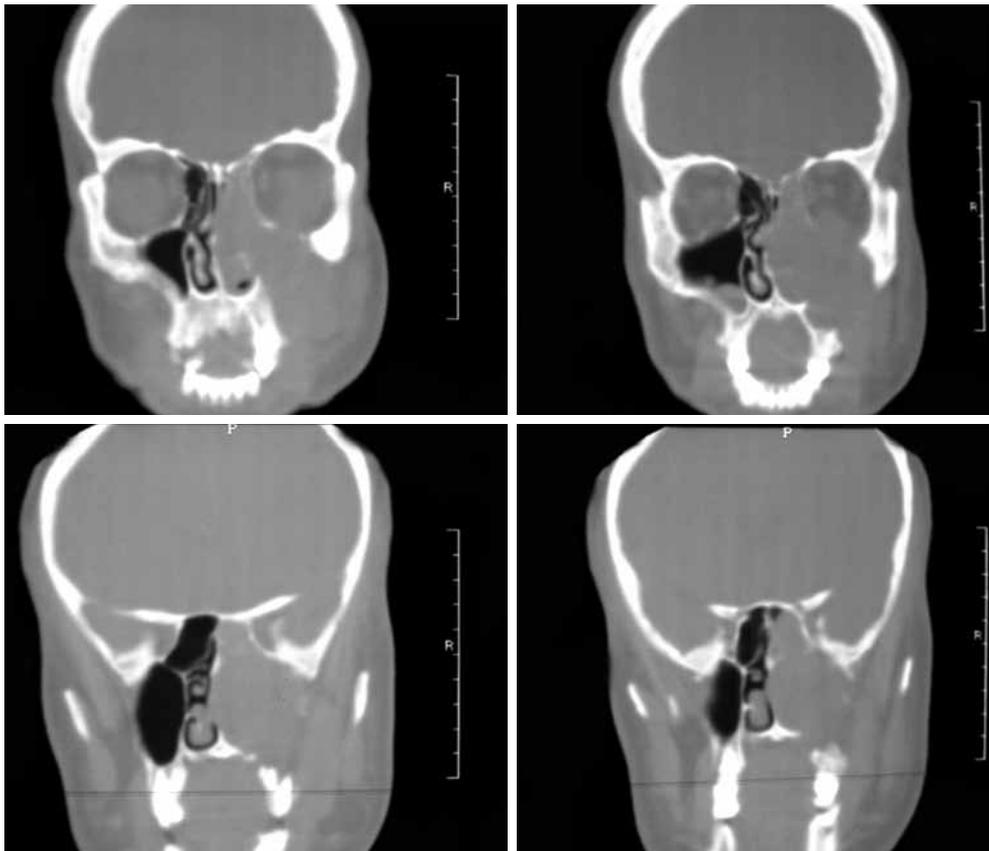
Preoperative coronal section paranasal computed tomography of case 1.
